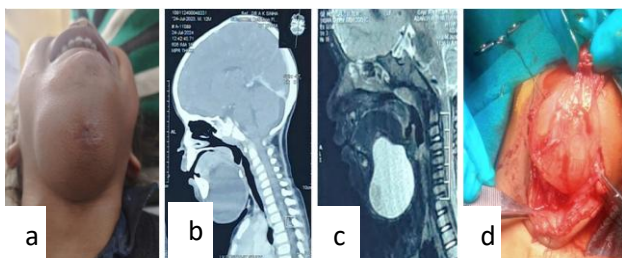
(a) Clinical image showing swelling in submental region with healed scar over it. (b) Sagittal film of CT showing cystic swelling in submental region. (c) Sagittal film of MRI showing cystic swelling in submental region. (d) Intra-operative image showing cyst.
